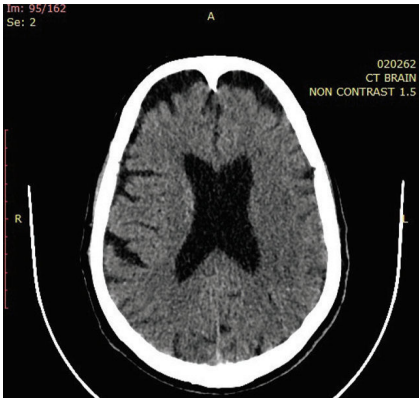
On the 24-hour follow-up computed tomography after thrombolysis, there is no development of infarction
